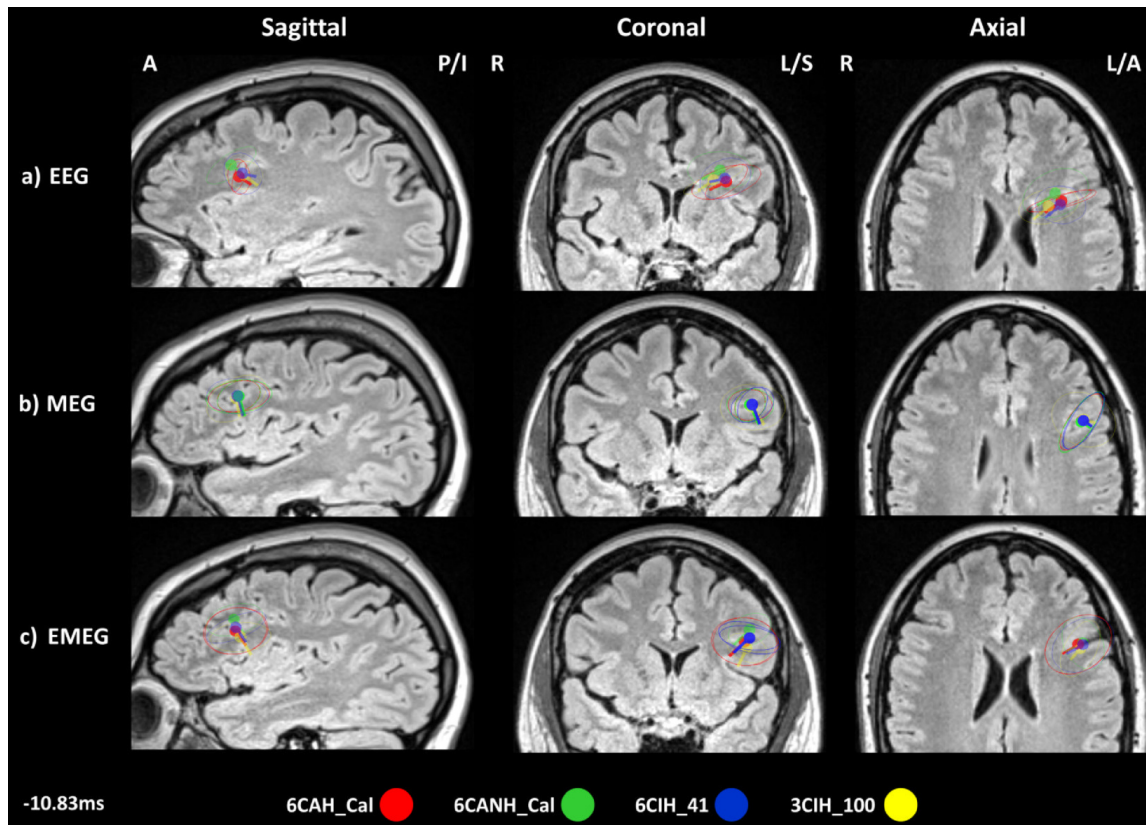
Head modeling effects on source reconstruction: a) The different head models used in the present study, the spike cluster centroids and spread ellipsoids (red for 6CAH_Cal, green for 6CANH_Cal, blue for 6CIH_41 and yellow for 3CIH_100) are depicted for a) EEG, b) MEG and c) EMEG at -10.83 ms. The source reconstructions are presented on the FLAIR MRI of the patient with sagittal (left column), coronal (middle column) and axial (right column) views. The centroid dipole locations of 6CHA_Cal were used for the selection of MRI slices and all results were projected on these slices. Anterior (A), Posterior (P), Inferior (I), Left (L) and Right (R) show MRI orientation.
